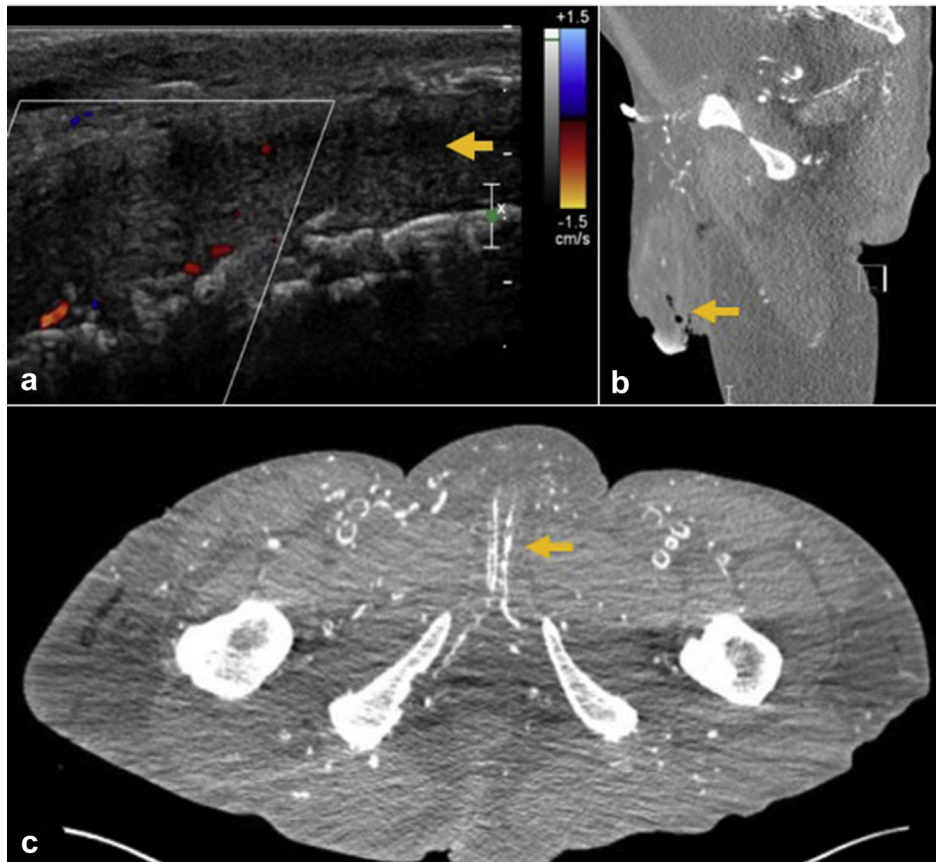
a) Penile Doppler ultrasound showing longitudinal view of right base of the penis, demonstrating lack of flow in cavernosal artery (arrow); b) Pre-operative non-contrast CT scan (sagittal view) showing gas in penile tissue (arrow); c) Pre-operative non-contrast CT-scan (axial view) demonstrating extensive calcification of the cavernosal arteries (arrow).
